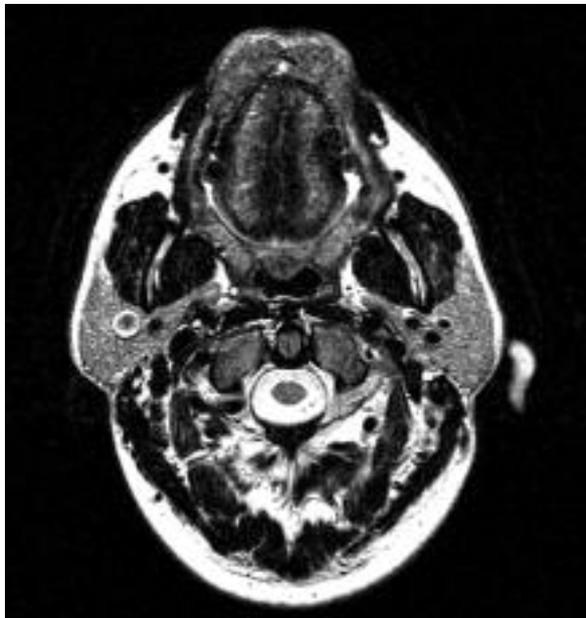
MR images depict the upper lip of the patient. Transverse fast spin-echo T2-weighted MR images (5,000/102; echo train length, seven; matrix size, 256 × 256; field of view, 150 × 200; section thickness, 3 mm; two signals acquired were obtained; acquisition time, 4 minutes); in the upper lip the presence of hyperplastic tissue with homogeneous iso-intense signal is clearly visible.
